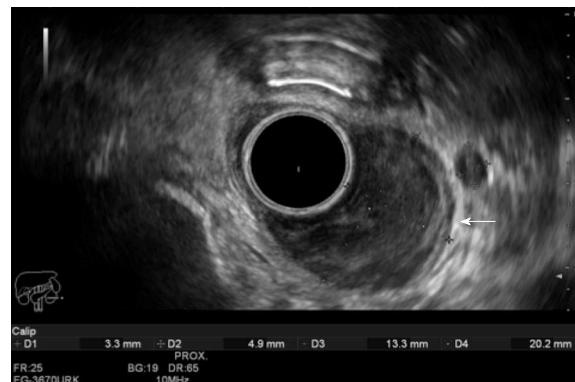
Esophageal carcinoma staging by endoscopic ultrasound T2 N1. The tumor is being measured (13.3 mm × 20.2 mm). It invades up to the muscularis propria (white arrow). A round, sharply demarcated and hypoechoic lymph node can be seen next to the tumor. EUS images were obtained using a Hitachi-Avius console with a radial scope EG-3630URK (from Pentax Medical). EUS: Endoscopic ultrasound.
